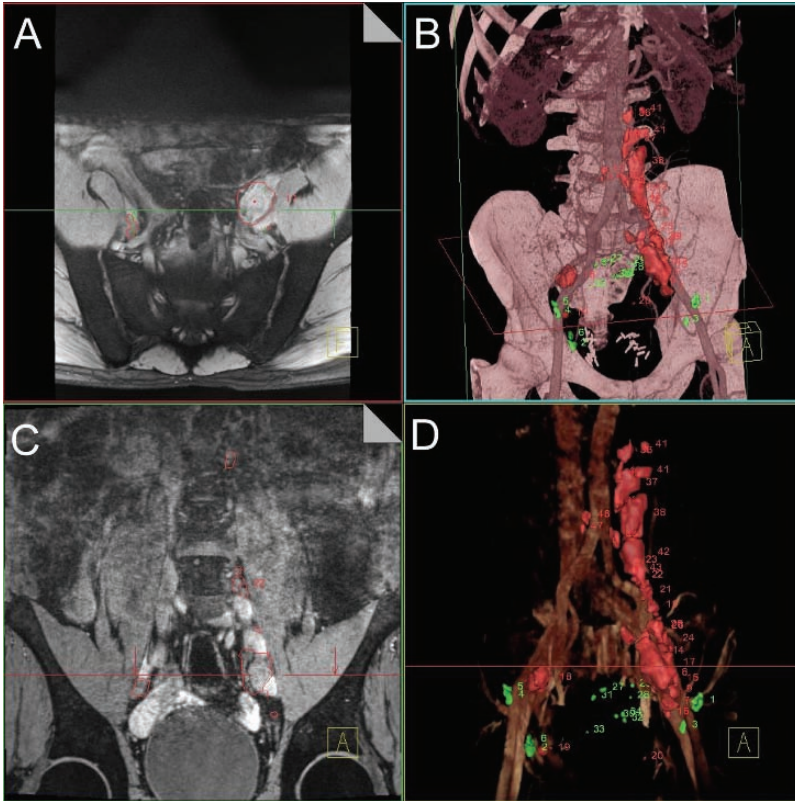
A 51-year-old patient with prostate cancer and generalized lymph node metastases. Siemens Task Card showing MR images (A,C,D) 24 hours post-ferumoxtran-10 and (B) CTA-MRL fusion. A High resolution T_2^* -weighted sequence. B MRL-CTA merged image showing pathologic nodes in red and normal nodes in green. With the help of a segmentation technique pathologic nodes (“white” on A and C) are indicated by a red color and normal node as green, and thus relation between vessels and nodes can be seen. C 3D T_2 -weighted sequence. D T_1 -weighted MRA sequence shows vessels and segmented nodes.
